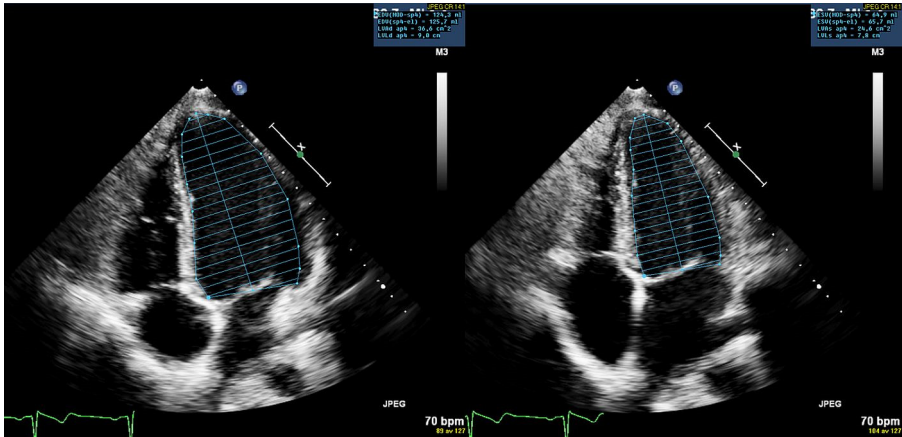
Apical 4-chamber view with delineation of the left ventricular end diastolic volume (EDV) seen to the left and left ventricular end systolic volume (ESV) seen to the right. Ejection fraction (EF) is calculated through the formula: $(EDV-ESV)/EDV$.
